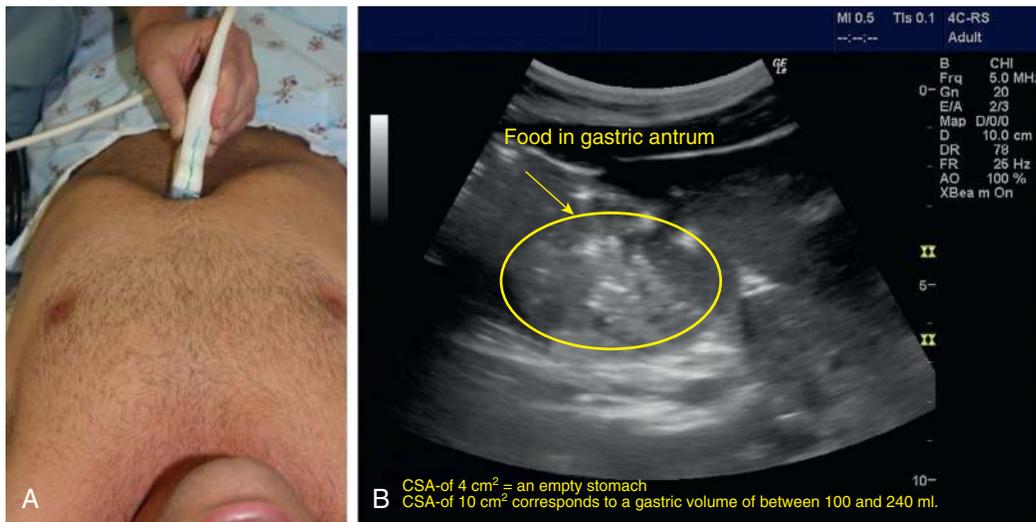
Ultrasound of Gastric Antrum to Assess Gastric Volume. A, Probe (curved linear) position for gastric antrum acquisition. B, Ultrasound image.
